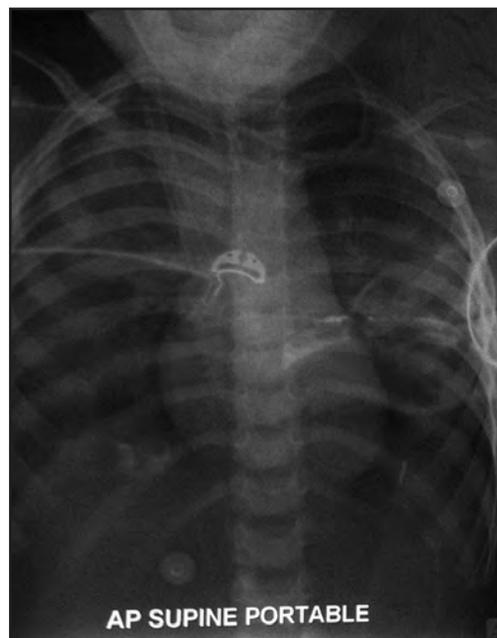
A follow-up chest radiograph (AP supine) showing progression of the consolidative changes into both lung fields (R>L) .
